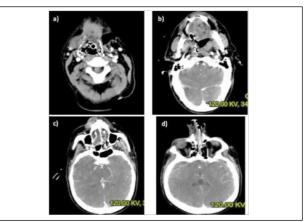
CT scan evidenced penetration of the FB through the left lateral region of the neck (a) below the jaw without causing its fracture (b). The pole then passed through the oropharynx and the palate, crossing the median line, penetrating the right paranasal sinuses and reaching the contralateral posterior ethmoid sinus (c). The penetration of the ethmoid caused a slight decomposed multi-fragmented fracture of the right papyral lamina with endo-orbital dislocation of some bony lamellae (d).
